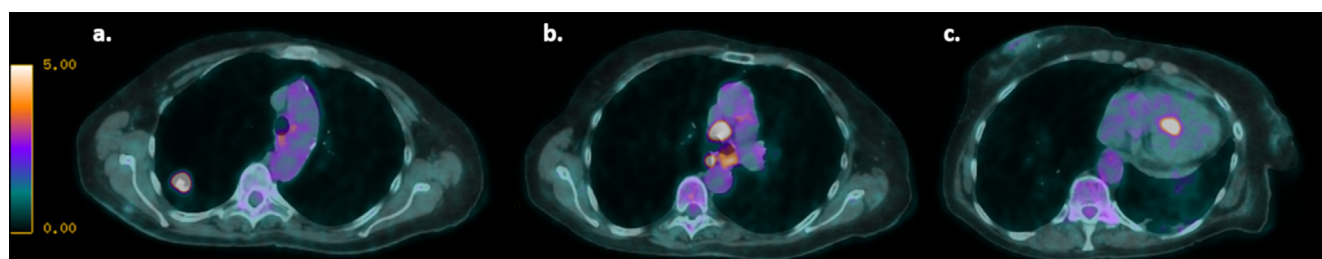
a. 18-FDG PET/CT scan in an axial view showing the hypermetabolic right upper lobe lung lesion; b. 18-FDG PET/CT scan in axial view showing active paratracheal lymph nodes; c. 18-FDG PET/CT scan in an axial view showing an hypermetabolic lesion within the heart.
